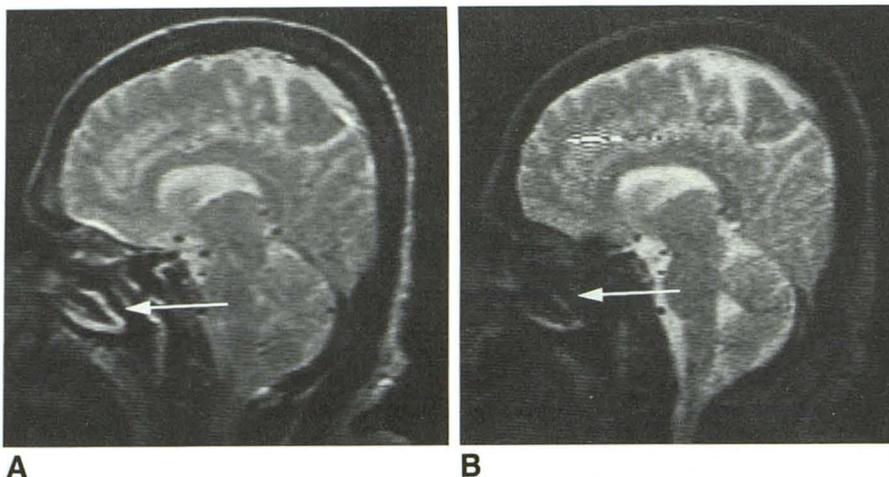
A and B, Fast T2-weighted MR images with low flip angle ( $30^\circ$ ). Spin-echo, 800/96 (A), and gradient-echo, 300/35 (B). Air/nasal mucosa interface (arrows) is clearly visible on spin-echo image, but because of magnetic-susceptibility-induced signal loss this region is not seen on gradient-echo image. Note also the little signal artifact obscuring gyrus rectus of frontal lobe, resulting from sinus air.
